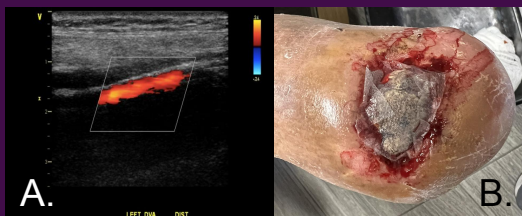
(A) Post-discharge duplex ultrasound (B) Amniotic membrane application to the ulcer with sufficient blood supply to the wound bed.
